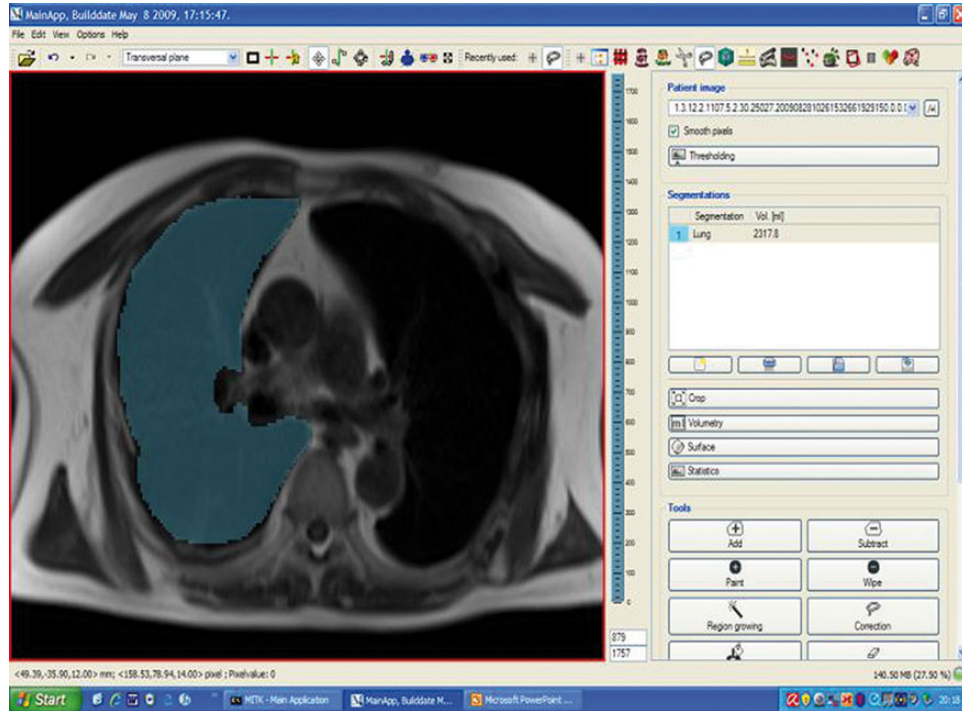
MRI examination: primary endpoint consisting of determination of the radiological vital capacity on the operated right side (difference between radiological total lung capacity and radiological residual volume).
